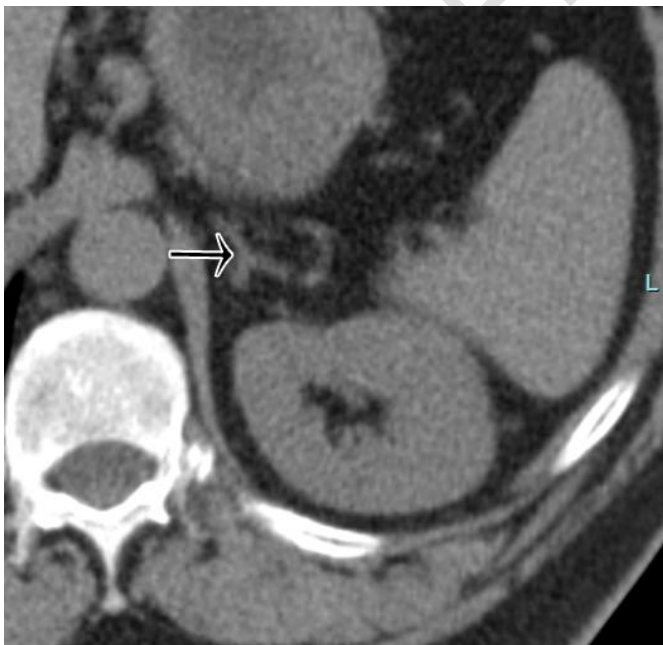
Abdominal CT showing the left adrenal gland in a medial and displaced position towards the interpolar region (→)
